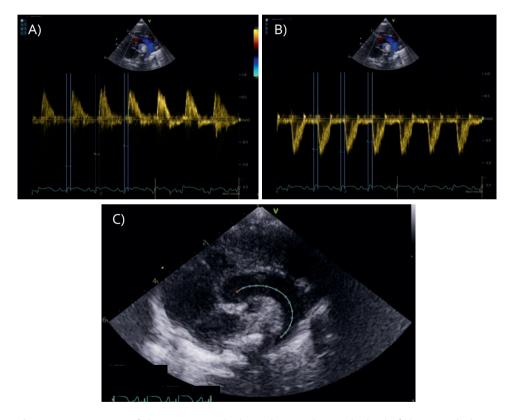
Measurement of the aPWV; A) pulsed Doppler recording at the level of the AV with three measurements of time until flow, B) pulsed Doppler recording at the descending aorta with three measurements of time until flow, C) length of the aorta from the location of pulsed Doppler recording A to pulsed Doppler recording B.
